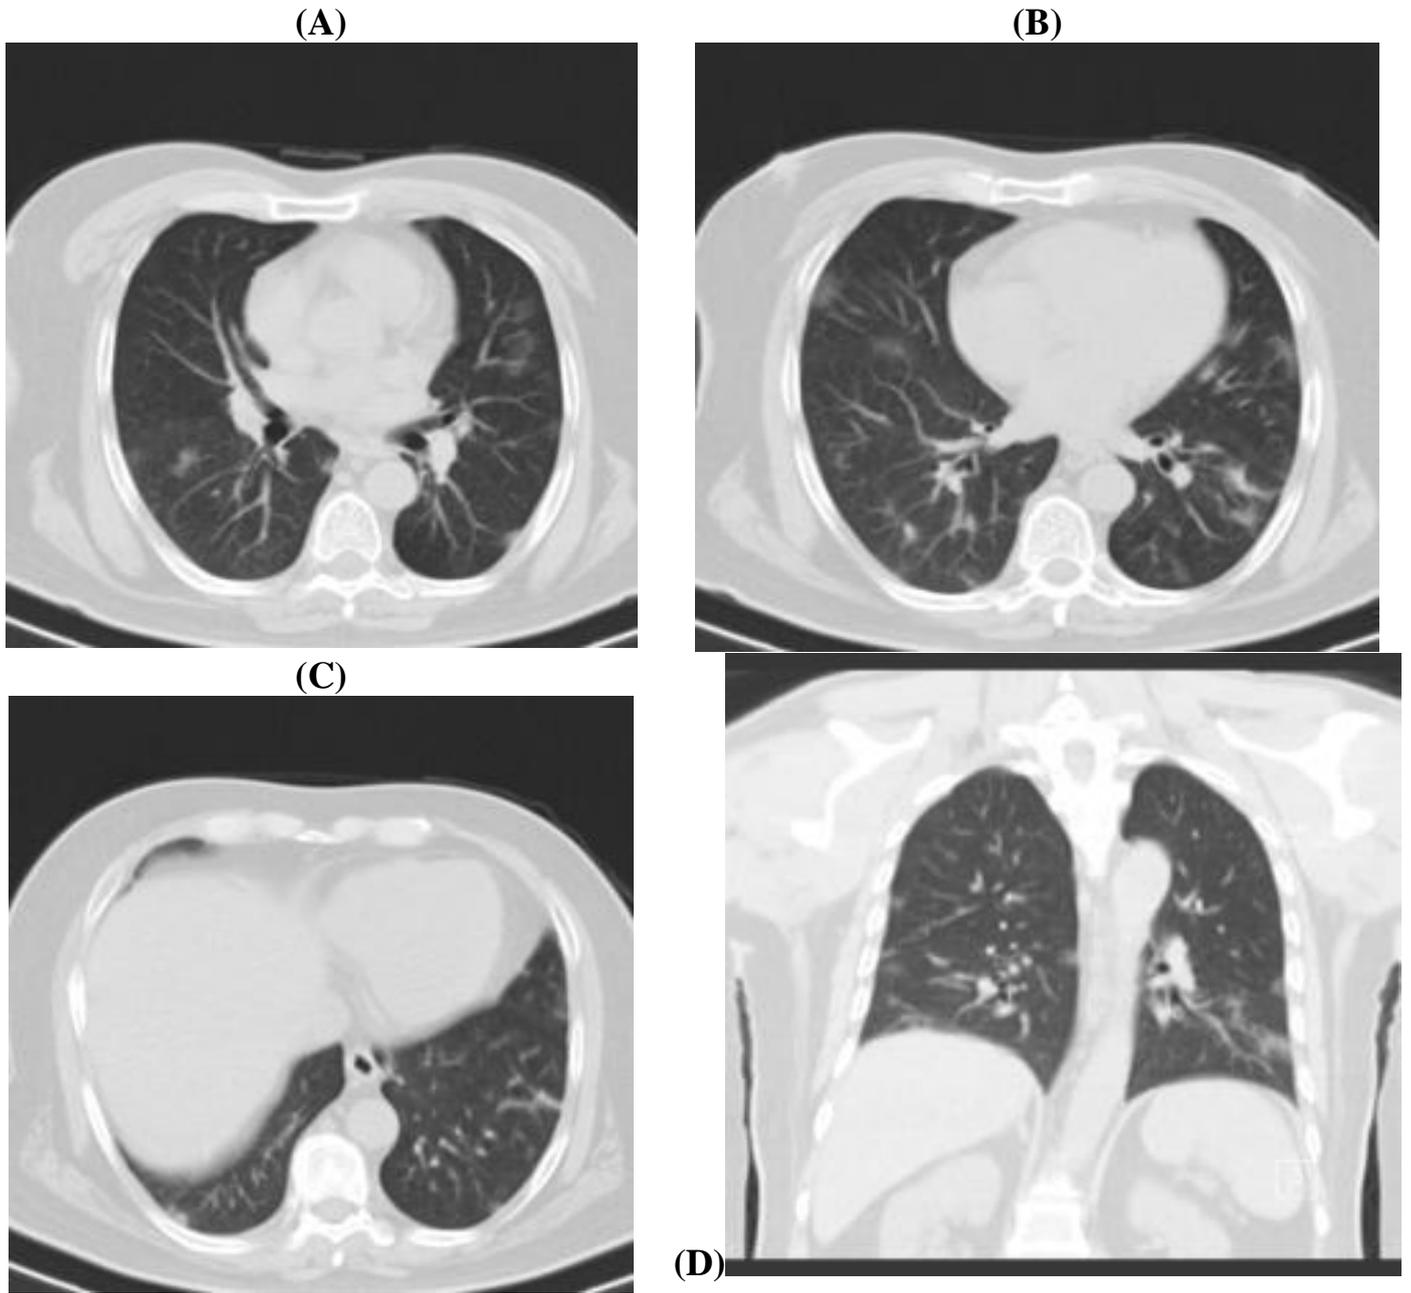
(A, B, C axial and D coronal): Male patient 50 y. Unenhanced chest CT scan shows bilateral and peripheral distribution of ground-glass opacities more dominant in the lower lobes. CT-SS was 7. The patient showed favorable course.
